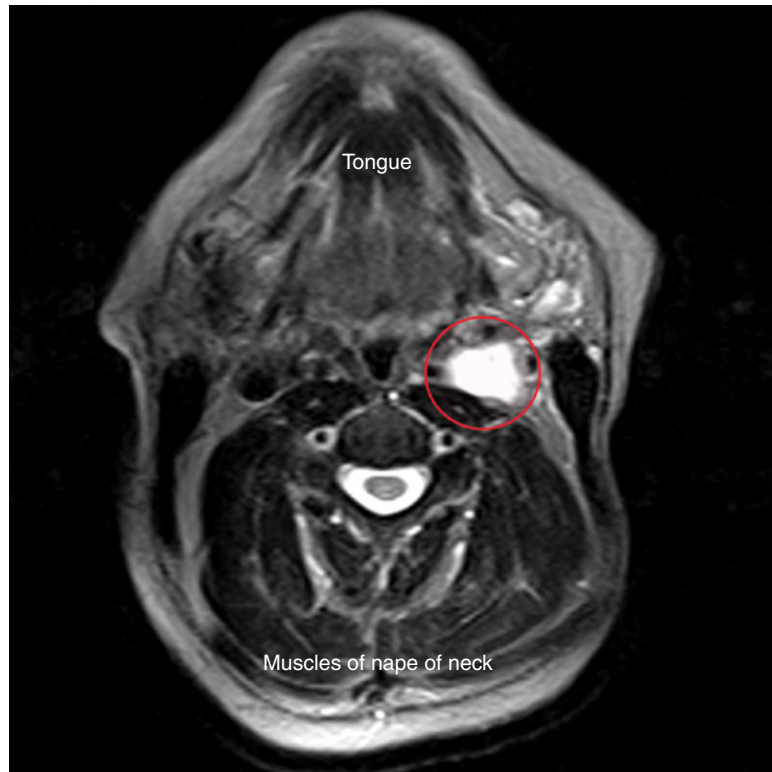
Axial section CT image of the upper neck of a patient in which a tumor (circled) encloses the glossopharyngeal nerve (this is not the CT scan of the patient in the case but a patient with an identical tumor on his left side; the published CT was not as clear as this one because it was done with an old CT scanner). Courtesy of Dr. Edward Weber.
